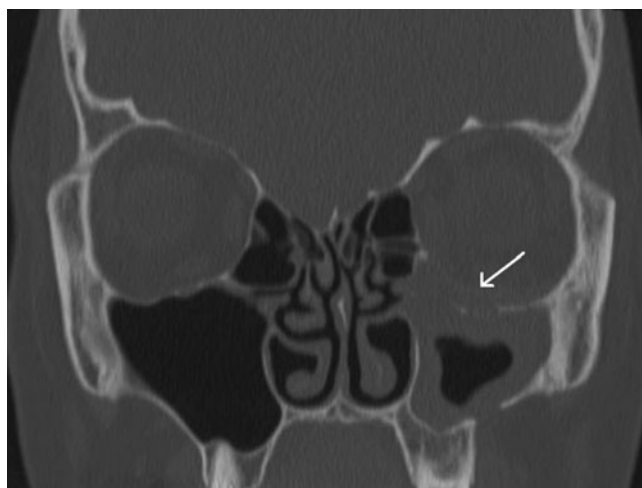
Coronal CT scan after orbital floor repair with a resorbable mesh (arrow points at mesh)
